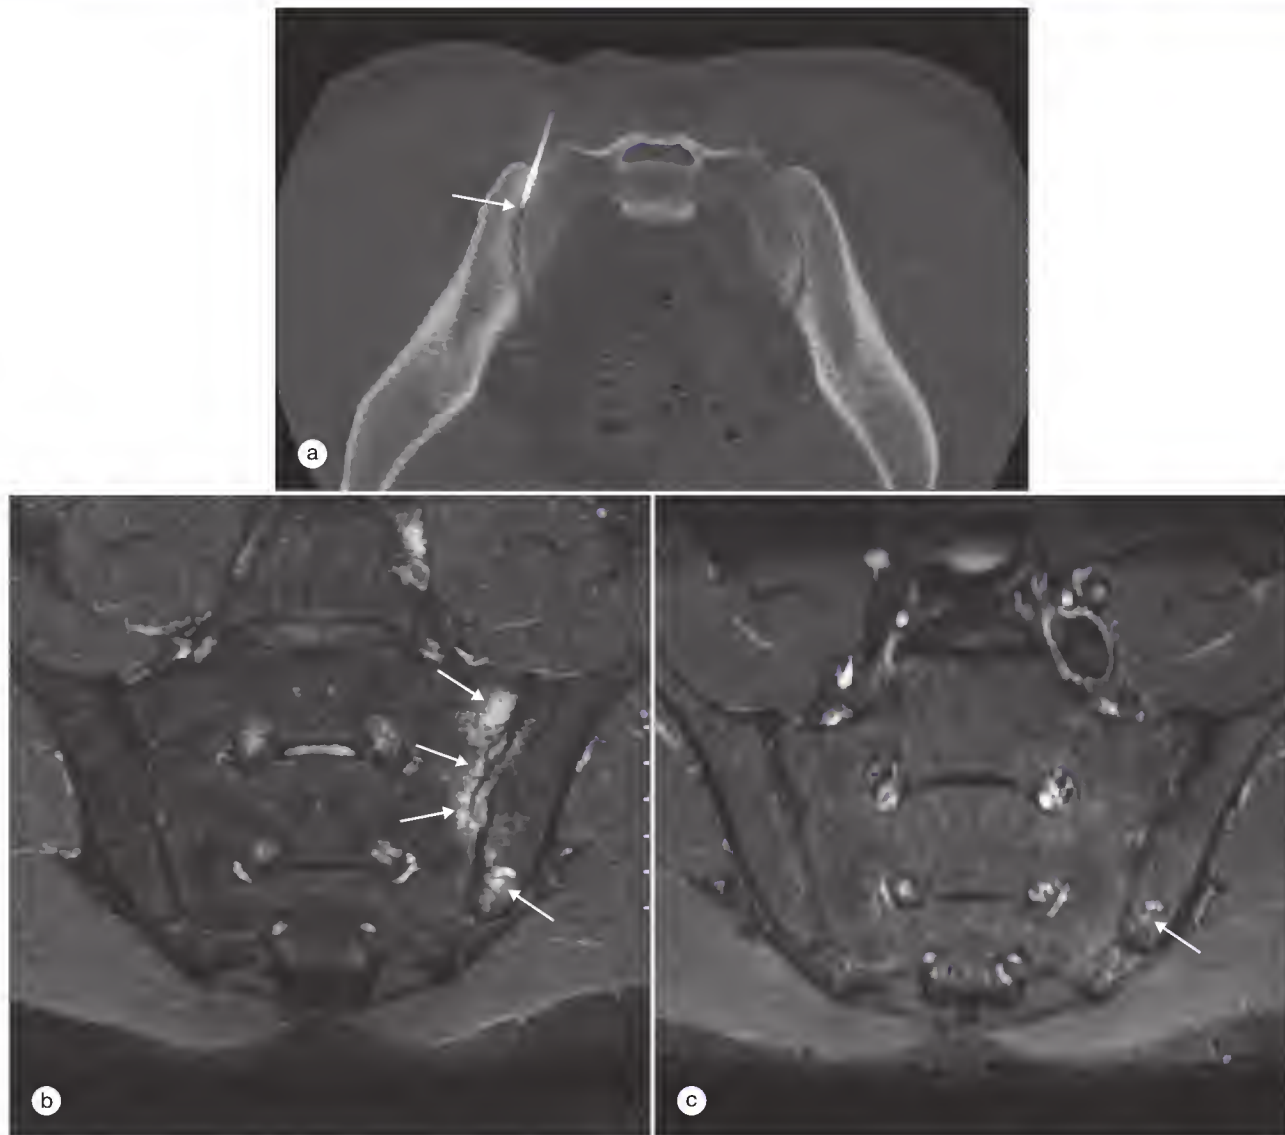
Intraarticular corticosteroid injection into the sacroiliac joints. (a) Computed tomography-guided intraarticular injection of 40 mg triamcinolone acetonide. The tip of the needle (arrow) is located deep in the joint space. (b) Magnetic resonance imaging (MRI) of the sacroiliac (SI) joints (short tau inversion recovery [STIR] sequence) of a 37-year-old patient with ankylosing spondylitis shows osteitis at the left SI joint (arrows) before injection. A small intraosseous cyst is seen at the dorsal part of the iliac bone (arrow on bottom right). (c) MRI (STIR sequence) of the SIJs 4 months after the injection shows complete resolution of the osteitis. As expected, no change is seen at the intraosseous iliac cyst (arrow). (Courtesy K.G. Hermann, Berlin.)
